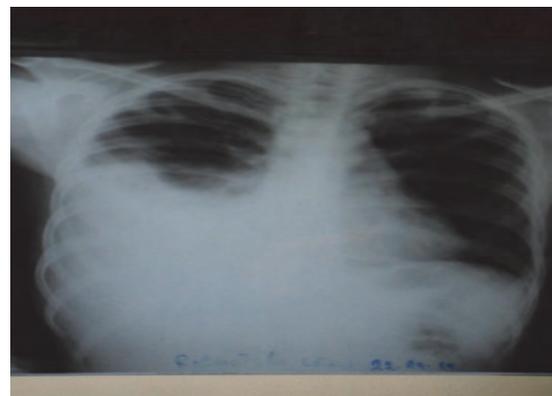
Chest radiography (X-ray) – large pleural effusion to the height of the front corners of IV ribs.
